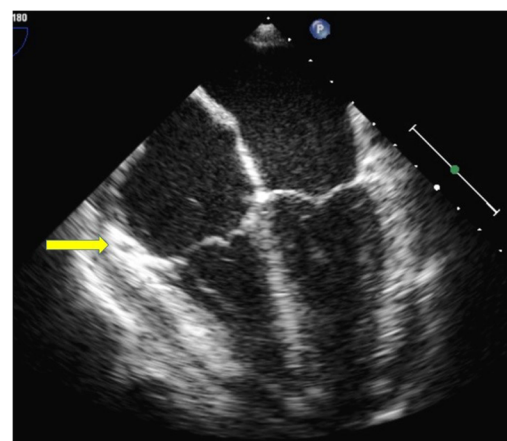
Transoesophageal echo. Hyperechoic and thickened pericardium around the ventricles (see arrow). No pericardial effusion is seen.
